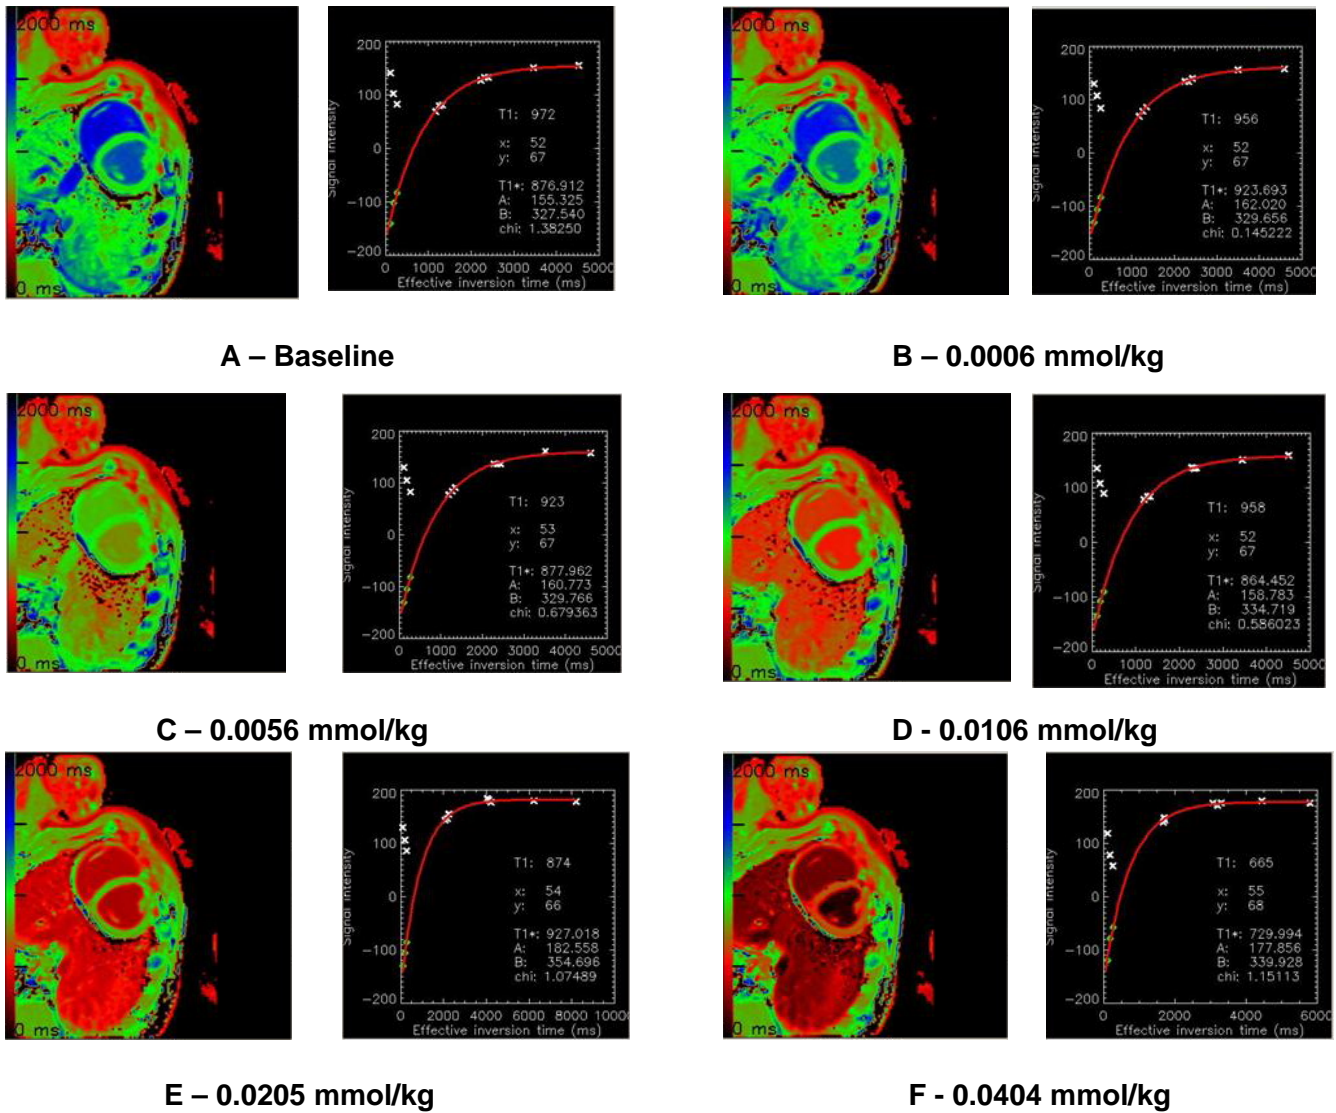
For the same subject shown in Figure 2, MRI images and corresponding T1 relaxation curve for the myocardium is shown for baseline (no contrast) and for accumulative doses of *Gadolinium*.
